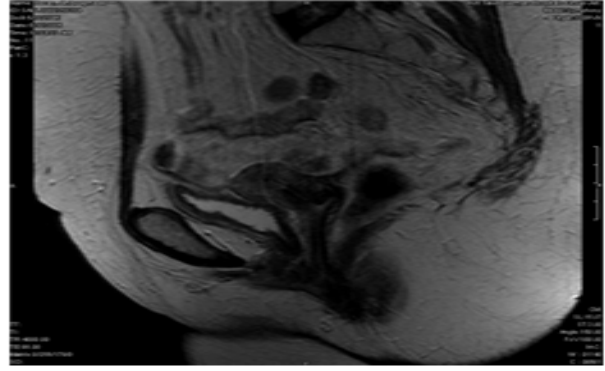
and 6 showed MRI comparative studies for three cases before and after neoadjuvant concurrent chemoradiation.
